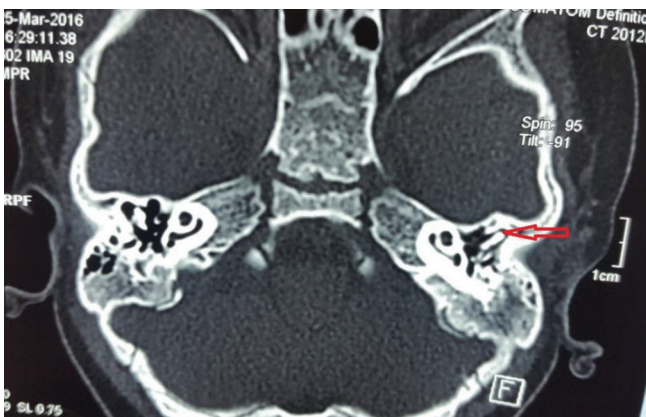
HRCT temporal bone with normal ossicles and middle ear.
